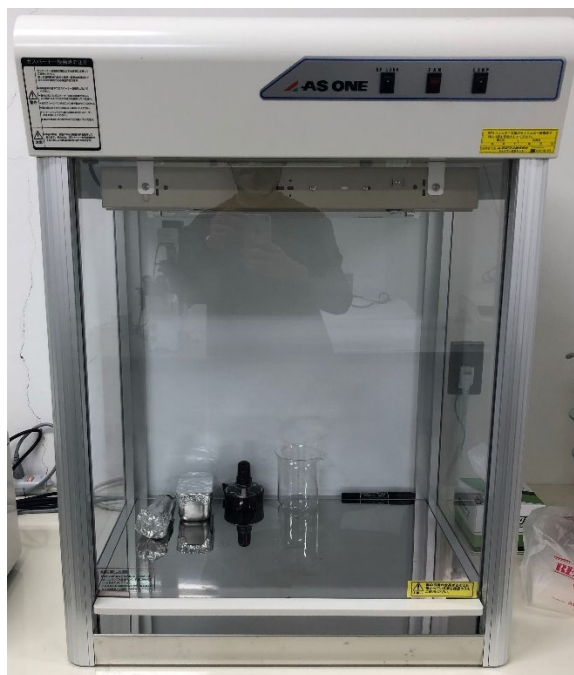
26 Clean bench (CT-600UVAD, AS ONE, Osaka, Japan).
